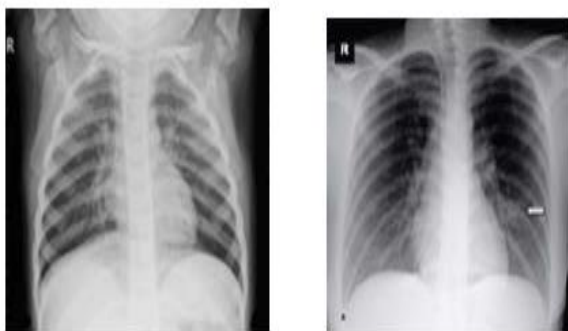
Detecting Corona infection through X-rays
